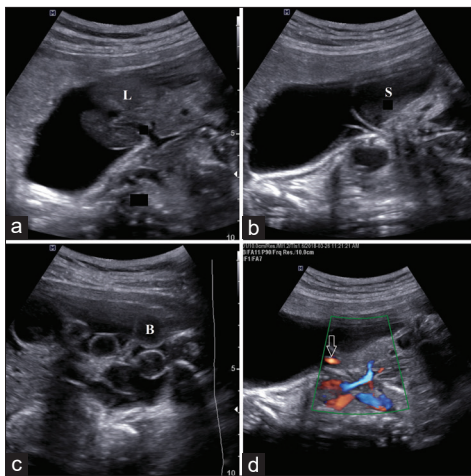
(a-c) Antenatal ultrasound scan showing anterior abdominal wall defect with herniation of bowel loops (B), stomach (S), and liver (L) through the defect. The herniated contents are freely floating in the amniotic fluid and are not covered by any membrane. The umbilical cord is seen on color. Doppler scan normally entering the abdominal wall (arrow in d)
